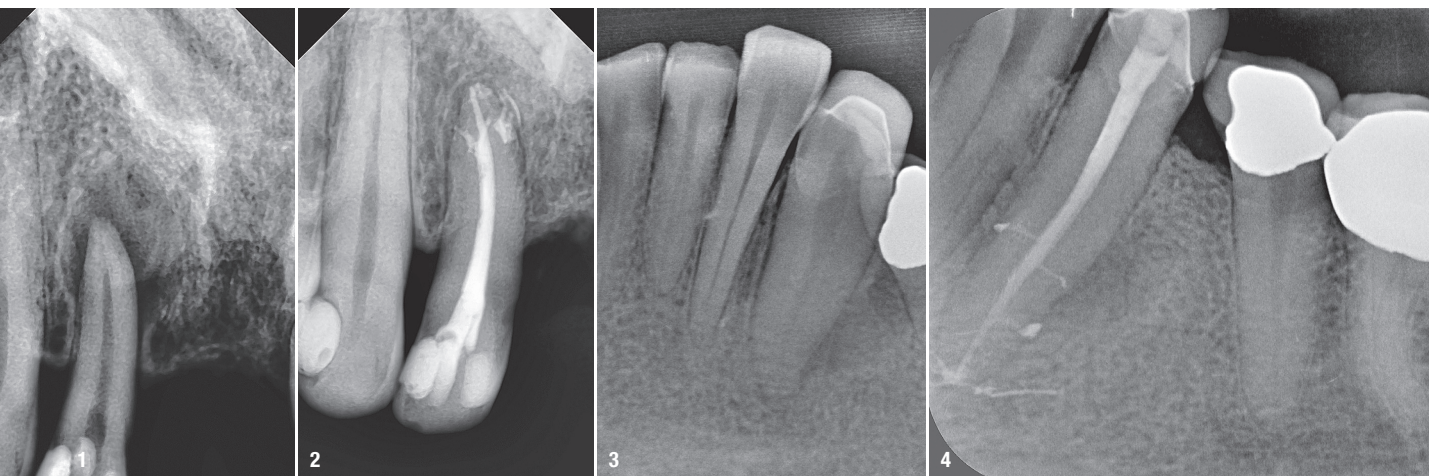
Tooth #12—the radiograph showed a large periapical lesion. The asymptomatic tooth was prepared with an ISO 25/06 TF Adaptive file (Kerr Dental). Fig. 2: Tooth #12—root canal filling was performed with mineral trioxide aggregate (ENDOSEAL MTA, Maruchi). Note the sealing of the apical ramification, possible because of the effective cleansing and decontamination of the apical terminus. There was almost complete healing after 12 months. Fig. 3: Tooth #33—the patient showed a buccal sinus tract that radiographically corresponded to the area between tooth #32 and tooth #33. The CBCT and radiograph showed a large periradicular lesion, especially on the distal side. Preparation was performed with a 20/.07v ProTaper Gold (F1; Dentsply Sirona). Fig. 4: Tooth #33—root canal obturation was performed with a sealer and carrier-based gutta-percha (AH Plus and Thermafil, Dentsply Sirona). The radiographic control six months post-op showed that several lateral canals had been filled and the healing process was in progress.
